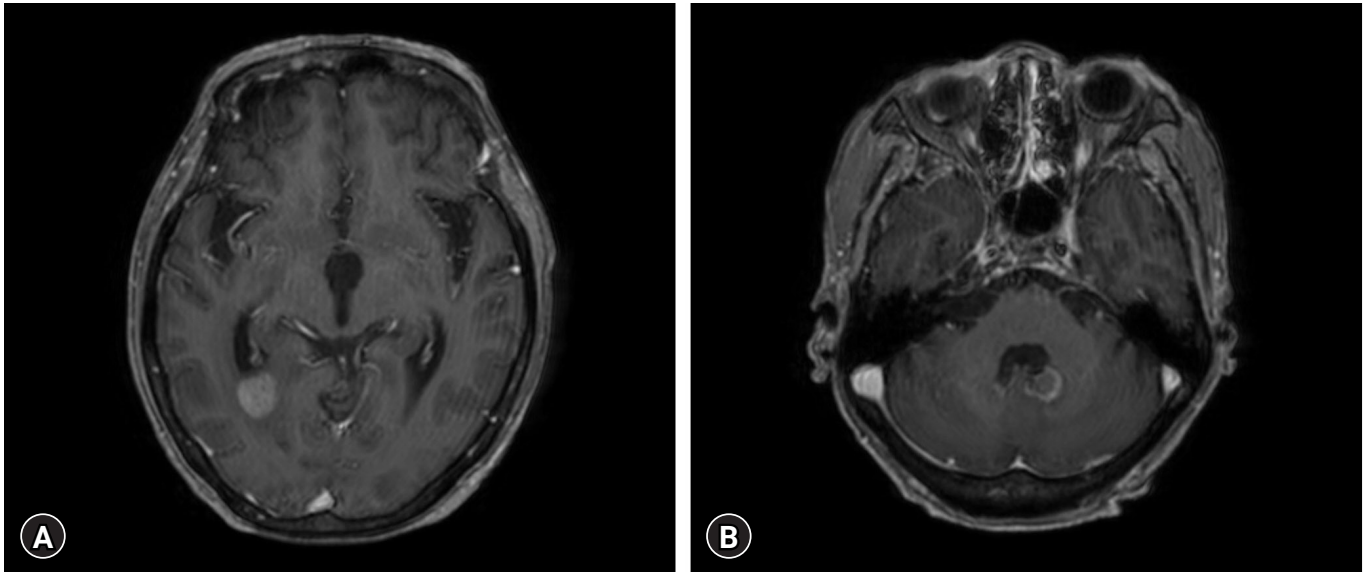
After 3 months of treatment, brain magnetic resonance imaging with gadolinium enhancement presented all the preexisting lesions have disappeared, but new hemorrhagic masses of approximately 1 cm were found in the (A) posterior horn of the right lateral ventricle and (B) left superior wall of the 4th ventricle.
